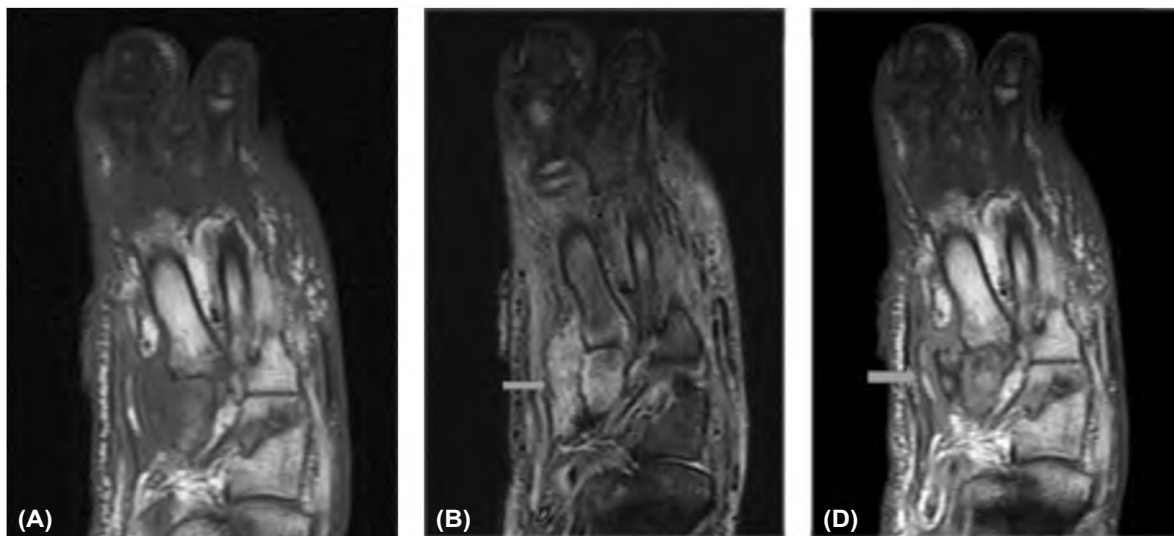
A 53-year-old female with diabetes and a non healing draining foot ulcer. The medial aspect of the mid-foot was swollen. There was agreement considering the presence of osteomyelitis and a soft tissue abscess between observers 1 and 2 using the rapid protocol and the clinical report for a full, contrast-enhanced protocol. (A) Coronal T1 pre-contrast non-fat saturated image shows confluent low T1 signal through the medial cuneiform and base of first metatarsal bone. (B) Coronal STIR shows high signal through the medial cuneiform with adjacent soft tissue collection. These findings meet classical MRI criteria for osteomyelitis and soft tissue abscess and the diagnosis could be reached using these two pulse sequences alone. Abscess presence was confirmed at surgery. (C) Coronal contrast-enhanced T1 non fat-saturated image shows the rim-enhancing fluid collection as seen on b (thick arrows).
